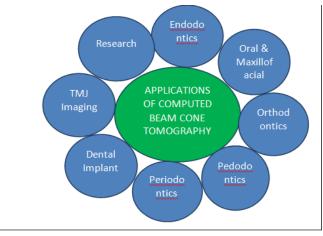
Applications of CBCT in various dental specialties.
